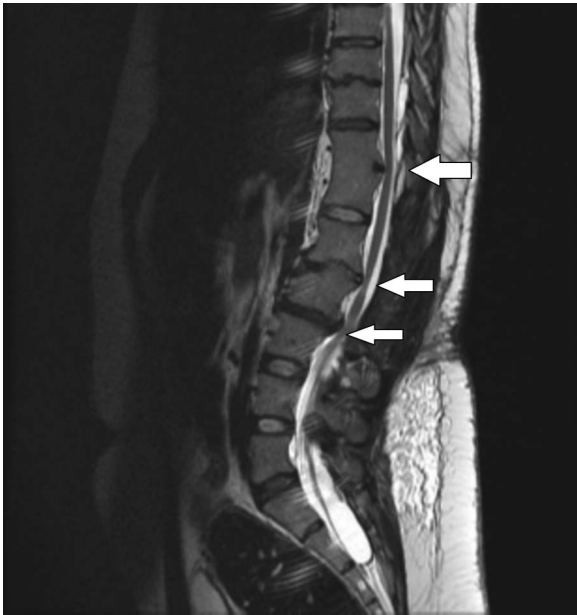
MRI, sagittal plane, of the thoracolumbar spine with spinal extradural arachnoid cysts (white arrows).
